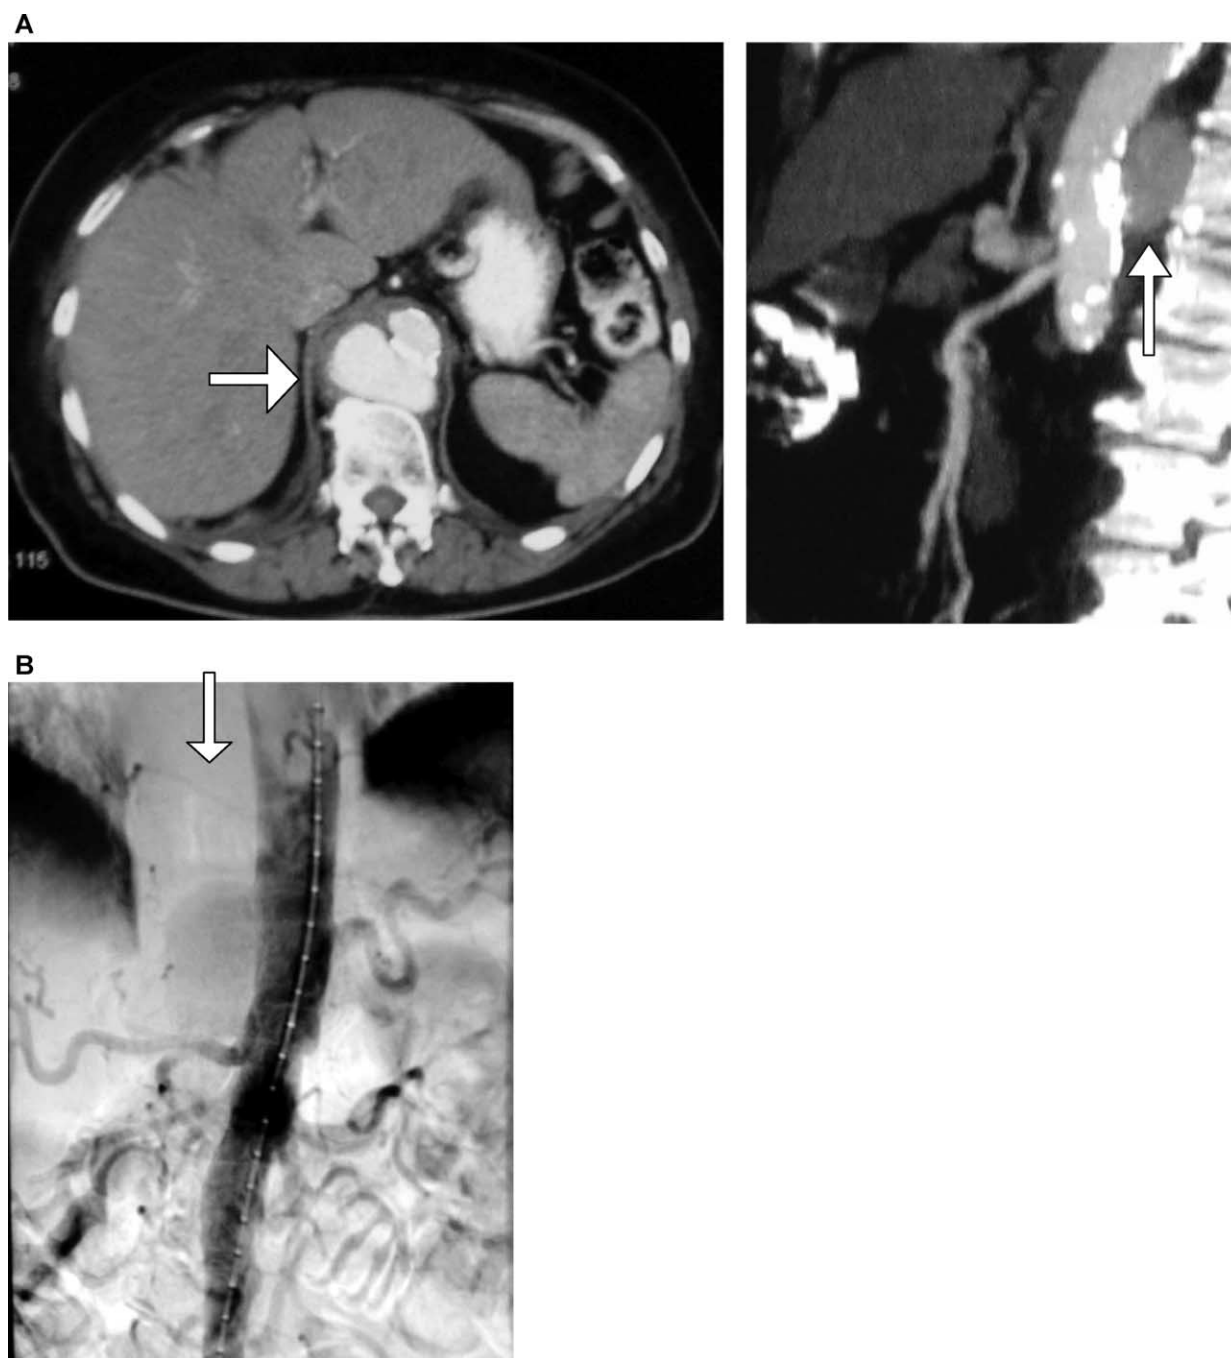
CT abdomen (A) and angiography (B) revealed the aneurysm spurium just above the celiac trunc. Aortic calcifications are present.
